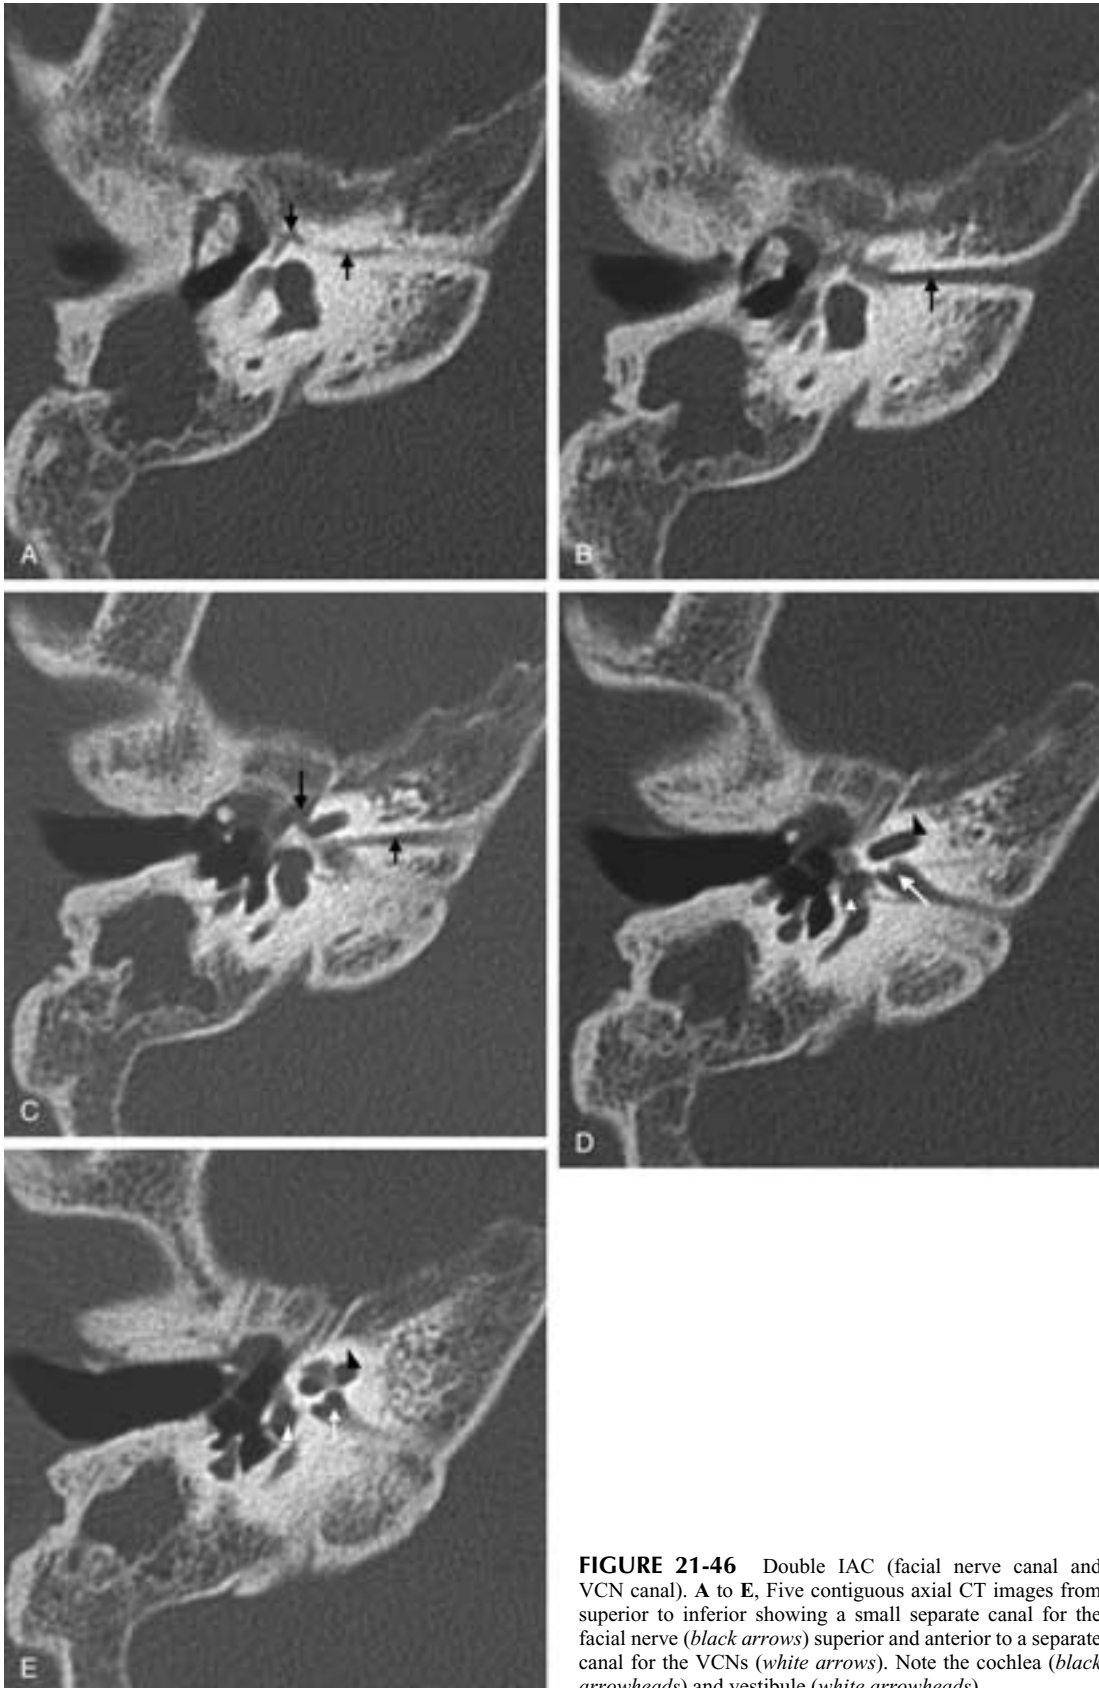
Double IAC (facial nerve canal and VCN canal). A to E, Five contiguous axial CT images from superior to inferior showing a small separate canal for the facial nerve (*black arrows*) superior and anterior to a separate canal for the VCNs (*white arrows*). Note the cochlea (*black arrowheads*) and vestibule (*white arrowheads*).
